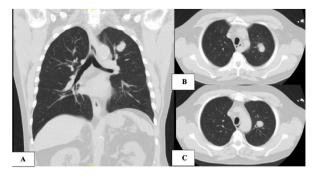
1A: Chest CT sagittal view with a LUL non-spiculated apicoposterior nodule 1B, 1C: Chest CT axial view demonstrating the bilobed nature of the apicoposterior LUL nodule.
